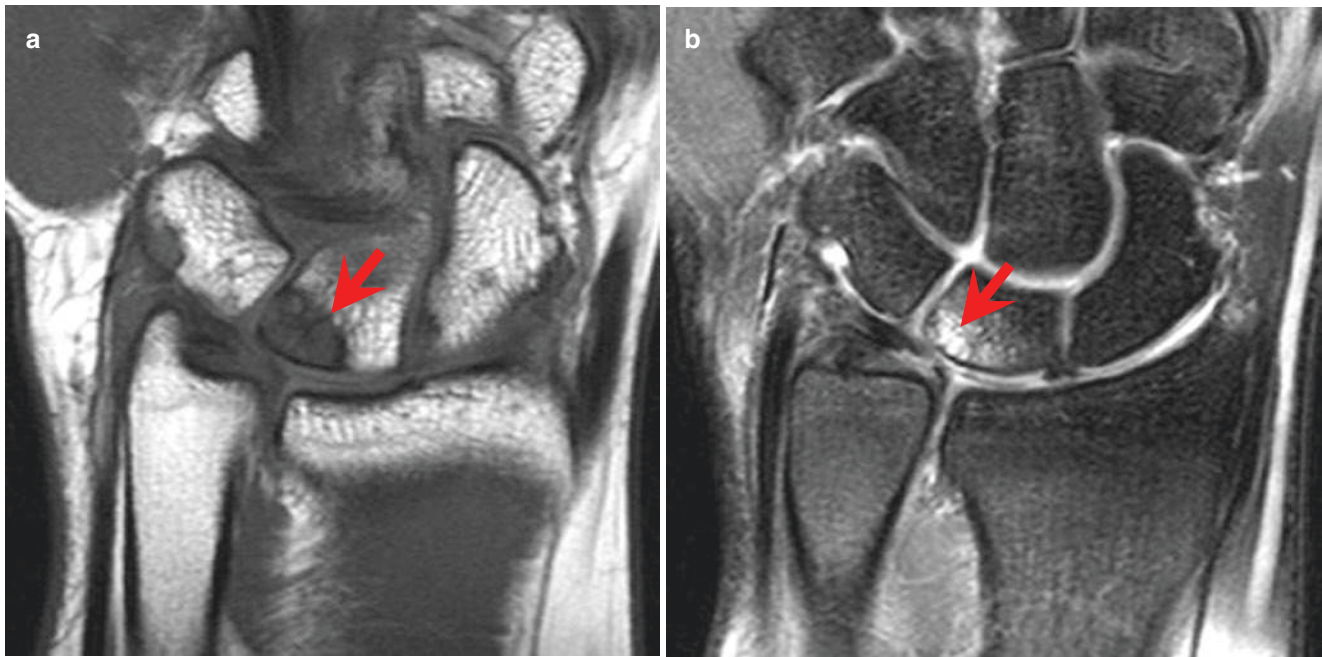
Ulnar impaction syndrome. 54-year-old woman with ulnar-sided wrist pain and “osteosclerosis” reported on radiographs. Coronal T1-weighted (a) and fat-suppressed intermediate-weighted (b) MR images demonstrate abnormal signal (*arrow*) centered in the subchondral
